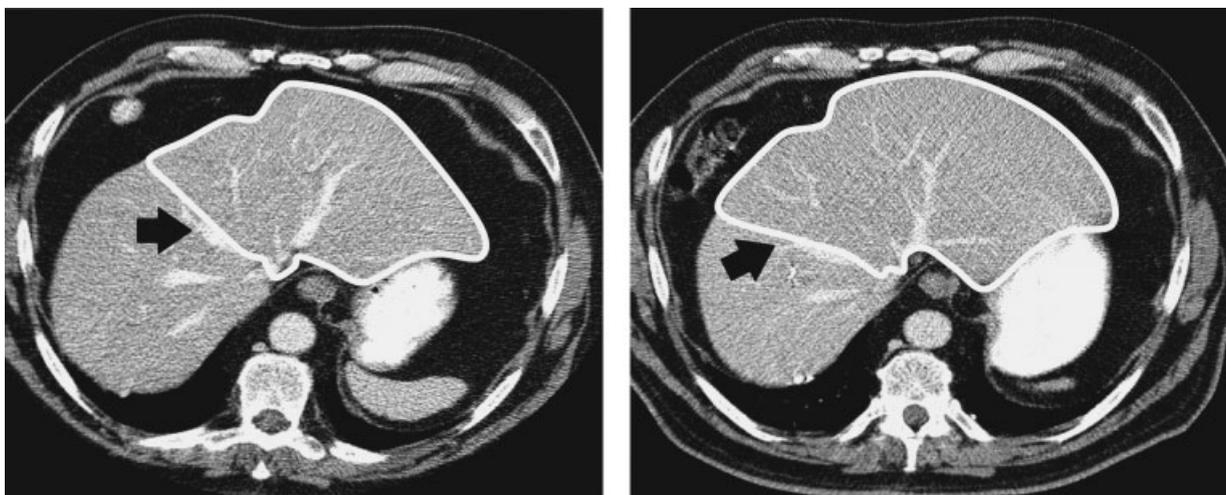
Hepatic venous phase of computed tomography in a patient with multifocal hepatocellular carcinoma involving the right liver before (left panel) and after (right panel) right portal vein embolization (PVE). The outlined left liver (with the main plane marked by the middle hepatic vein, arrow) increased from 36 to 46% of the standardized total liver volume as a result of PVE. Six days after an uneventful right hepatectomy, the patient was discharged from the hospital. The patient did not experience ascites, fluid retention, or cholestasis at any time during the postoperative course.
